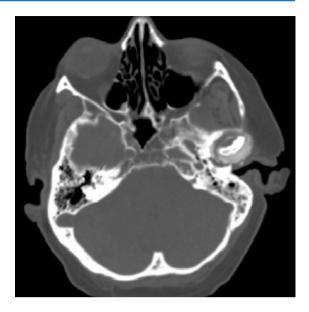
CT axial view shows a cloud-like calcification in the joint space surrounding the left condyle. This is one of the radiographic features of CPPD deposition disease, but chondrosarcoma can mimic this appearance and thus should be ruled out
